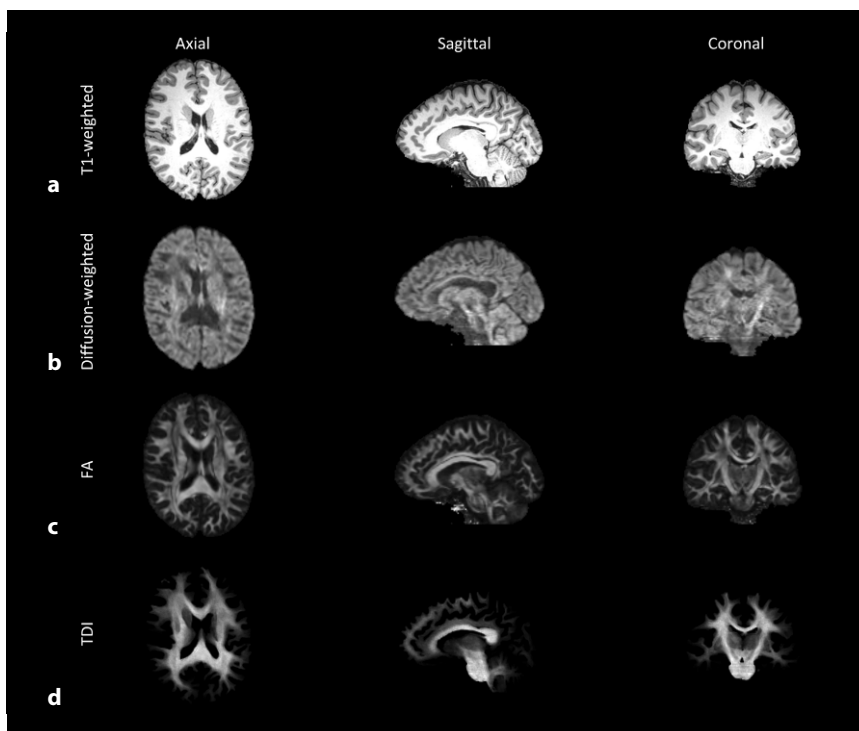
▲ T1-weighted and dMRI-derived sample images. a T1-weighted images. b Single post-processed diffusion-weighted volume acquired with b -value = 1600 s/mm^2 . c Map of fractional anisotropy (FA) describing anisotropy of local diffusion. d Track-density imaging (TDI), tractography-derived contrast obtained by mapping density of streamlines. (Image courtesy of Otto von Guericke University Magdeburg)
